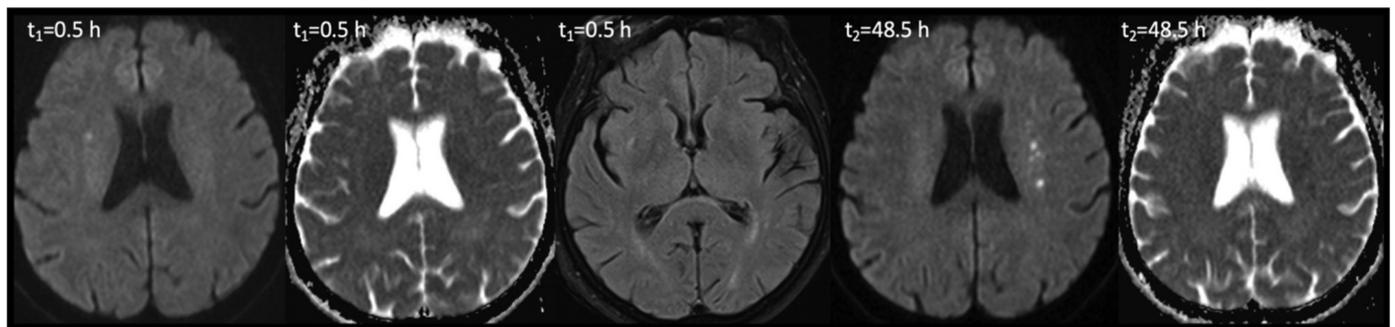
Pure penumbral stroke. A 76-year-old woman with known prior history of hypertension and coronary artery disease was consulted while she was being followed at the cardiovascular and chest surgery department after a coronary artery by-pass graft surgery. Transcortical sensorial aphasia and a left-sided central facial paresis were found on examination (admission NIHSS: 7; 24th-hour NIHSS: 6). Diffusion restriction is not seen in DWI, which is completed a half-hour after the onset of the symptom. However, distal left MCA segment occlusion is detected on CT angiography. The vessel signs in FLAIR sequences are indirect markers of perfusion deficit are visible. In the second imaging taken 48 hours after the first one, the culprit lesion can be clearly detected as DWI bright and ADC dark ischemic lesion. There was no change in the patient's neurologic deficit during the interval
